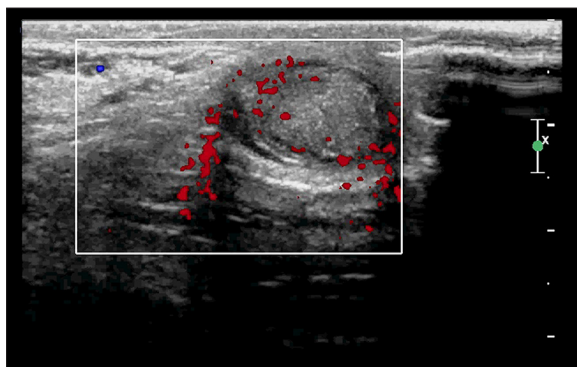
40-year-old man with polyorchidism. The vertical color Doppler ultrasonography image of an extra testis shows similar vascularity pattern with normal testis parenchyma.
